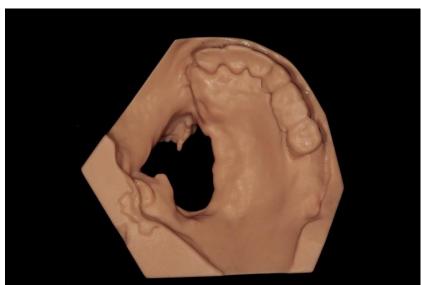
Digitally printed anatomical 3-D model acquired from patient's medical grade CT
